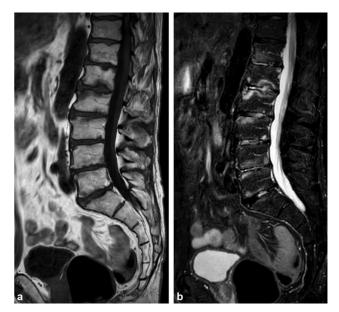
(a) Sagittal T1-weighted turbo spin-echo (T1TSE) and (b) short tau inversion recovery images (STIR) of the lumbar spine in a 70-year-old man with axial spondyloarthritis with structural lesions and active disease. The anterior end plates show erosions. All end plates show irregularities and disk height loss with bone marrow edema.
